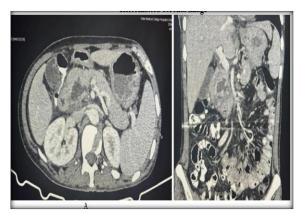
Case of serous cystadenoma of pancreas. Contrast enhanced computed tomography scan of a 40-year-old male patient shows multicystic lobulated mass in the pancreatic head. (A) Axial image. (B) Reformatted coronal image
